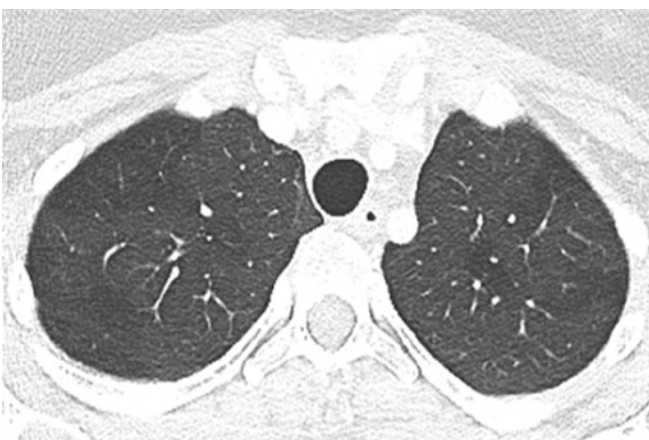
A 17-year-old girl who is status post-bilateral lung transplant 2 years ago and presented with worsening shortness of breath. Axial lung window CT image obtained at end-inspiration (left) shows
